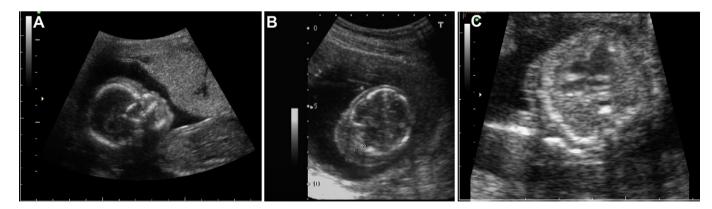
Prenatal ultrasound in Case 1 shows (A) nasal hypoplasia, (B) nuchal edema, and (C) endocardial cushion defects.
